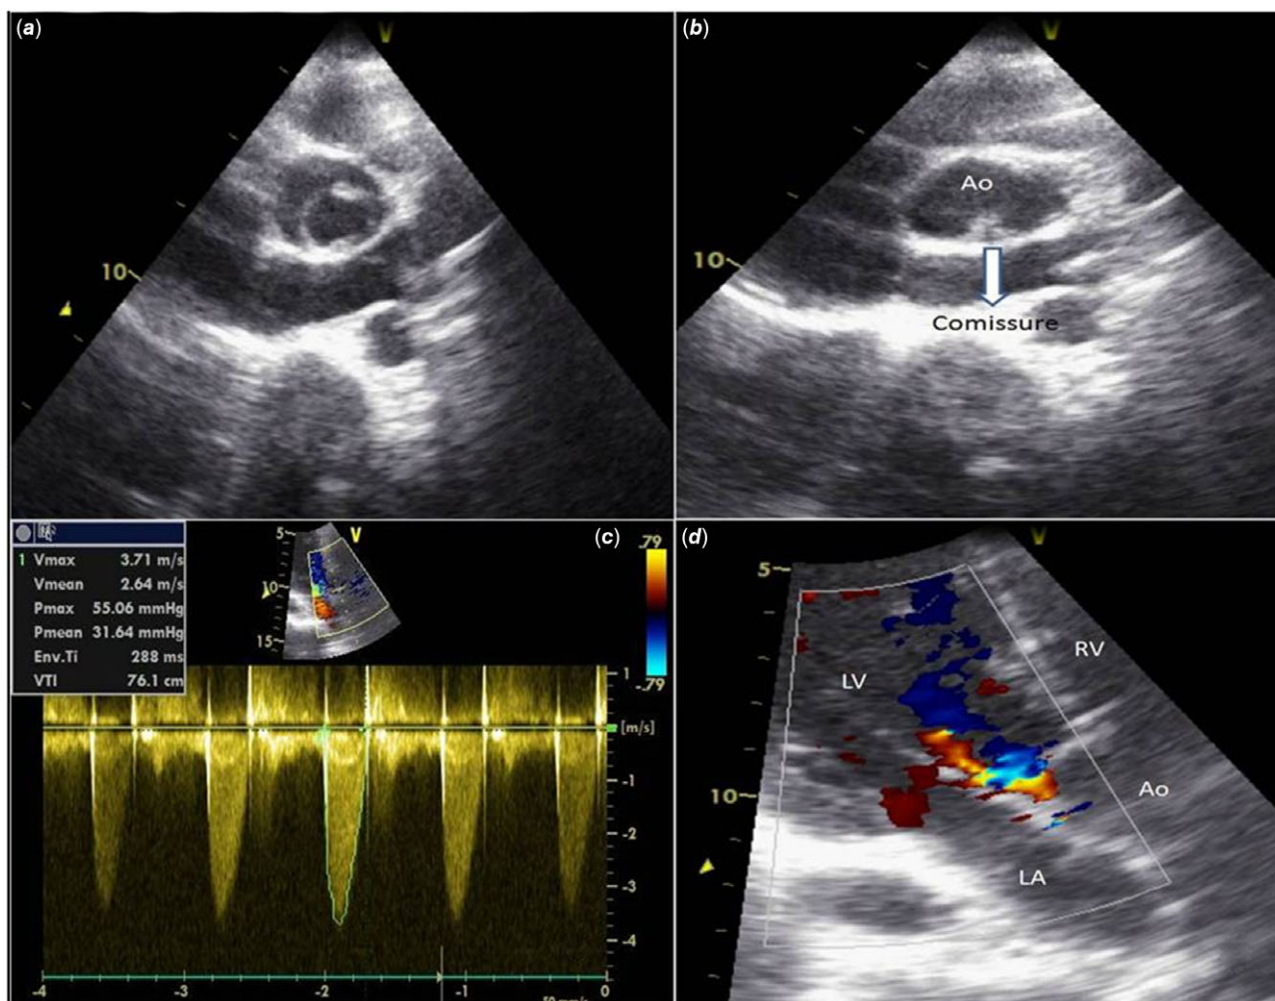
(a, b, c and d) Transthoracic echocardiogram in parasternal short-axis view demonstrating (a) a unicuspid aortic valve with an eccentric orifice in systole, (b) in diastole with one commissure at 6 o'clock, (c) moderate aortic valve stenosis by continuous-wave Doppler, (d) eccentric mild aortic valve regurgitation.
